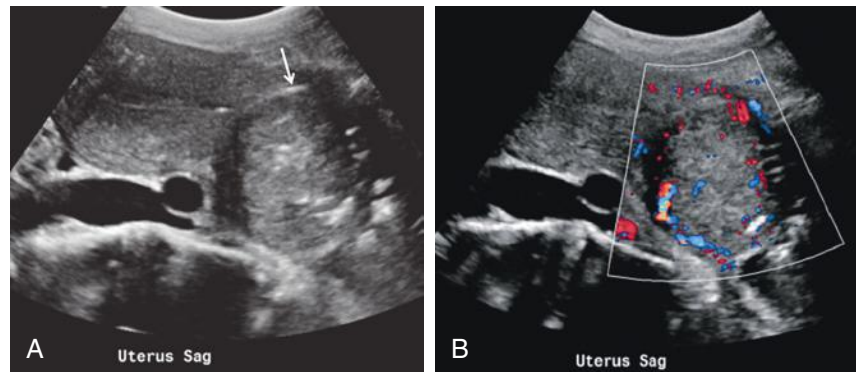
Cervical carcinoma. Sagittal gray-scale (A) and color Doppler (B) images of the uterus reveal a heterogeneous well-defined, sharply margined vascular cervical mass compressing the iliac vessels posteriorly. The endocervical canal (arrow in A) is displaced anteriorly and partially obliterated, suggesting that the mass might have originated from the endocervical canal. There is no evidence of parametrial invasion nor is there extension into either the lower uterine segment or vagina, although the mass is large. However, the sonographic appearance is nonspecific and could be mimicked by a cervical leiomyoma.
